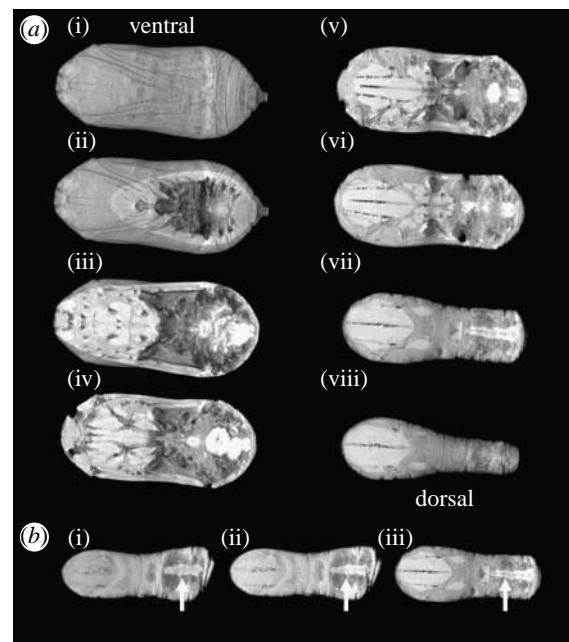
MRI of living pupae during development. (a) An example of the MRI slices in the ventral to dorsal direction ((i)–(viii)) of a pupa just before the adult emerged (100%D), revealing various internal organs such as the heart (slice vii). (b) The heart is shown during development; morphological changes occurring during the 80–100%D stages are clearly seen ((i) 60%D, (ii) 80%D, (iii) 100%D). The heart is approximately 52% thinner and approximately 15% longer in the 100%D stage than in the 60%D stage, and is much denser (brighter intensity in the 100%D image) consistent with the previous literature (Gerould 1929).
